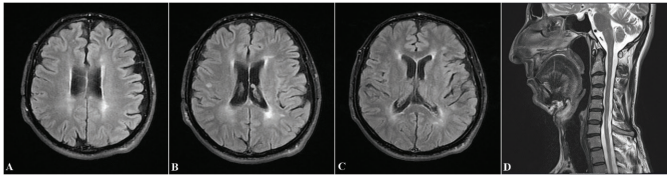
A, B, C. Periventricular, subcortical, and deep white matter hyperintense lesions are seen on the fluid-attenuated inversion recovery (FLAIR) images. D. T2-weighted images reveal hyperintense lesions and a slight volume loss of the cervical spinal cord
